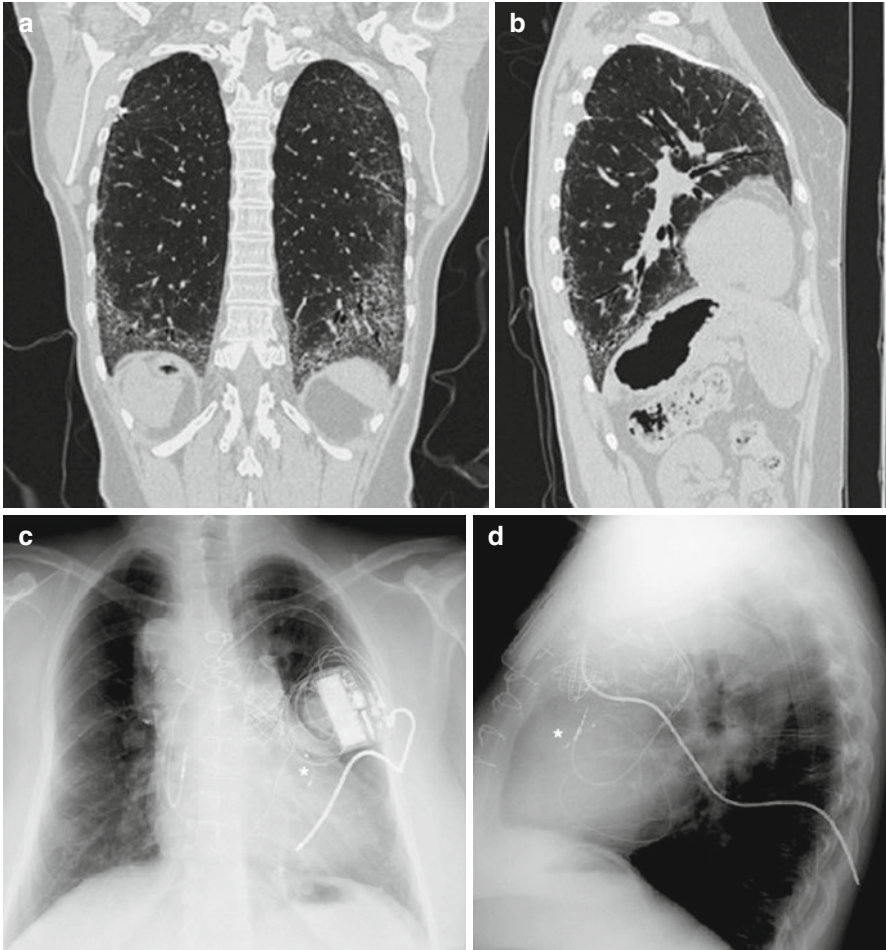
Chest CT in coronal (a) and sagittal (b) view. Chest radiograph in a posterior-anterior (c) and lateral view with heart indicated by * (d) (c, d: Used with permission of Springer Science+Business Media from Gupta et al. [18])
